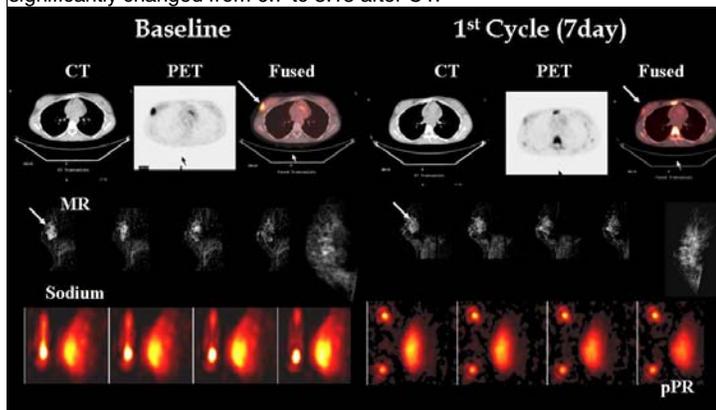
Demonstrates low FDG uptake on an invasive lobular breast cancer, that is clearly visualized using proton and sodium MR. Similar trends were noted on this case with the changes in MR and sodium volume and the patient had a pPR after PST.
